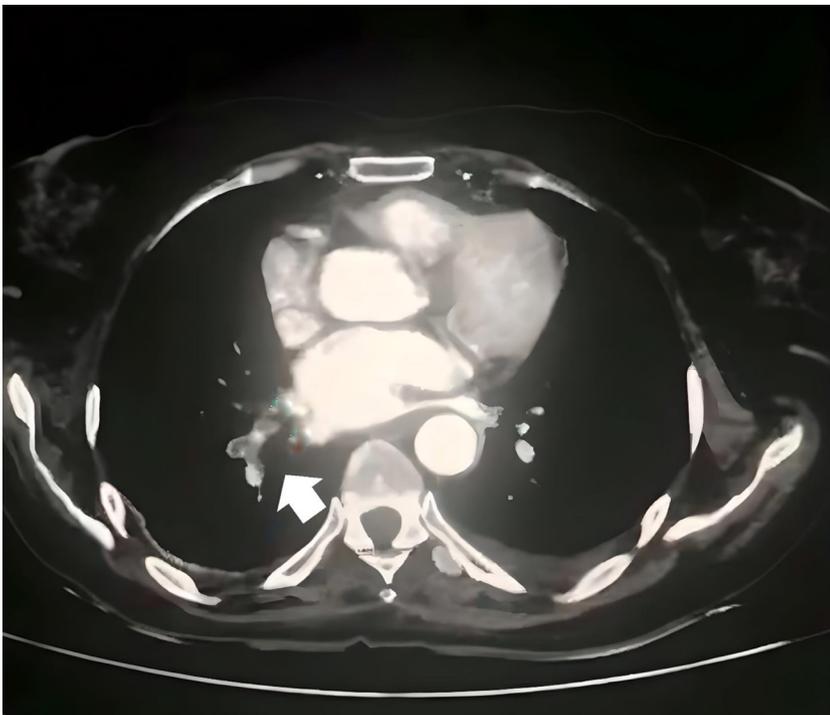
Axial CT pulmonary angiography showing a segmental PE (pointed to with arrow) in the posterior-basal branch of the right lower lobe pulmonary artery. The filling defect is well-demarcated and located peripherally, consistent with segmental PE contributing to pulmonary infarction
